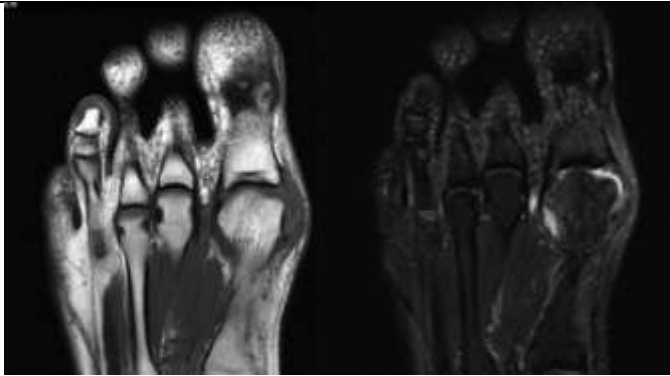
MRI slice T1-Axial (left) and T2-Axial (right) that demonstrates the medial first MTPJ capsuloligamentous tear with discontinuity of the dark capsuloligamentous structures and edema noted on the T2 (right). The lateral capsuloligamentous structures are intact (dark band from lateral proximal phalanx base to metatarsal head) for side comparison on both images.
